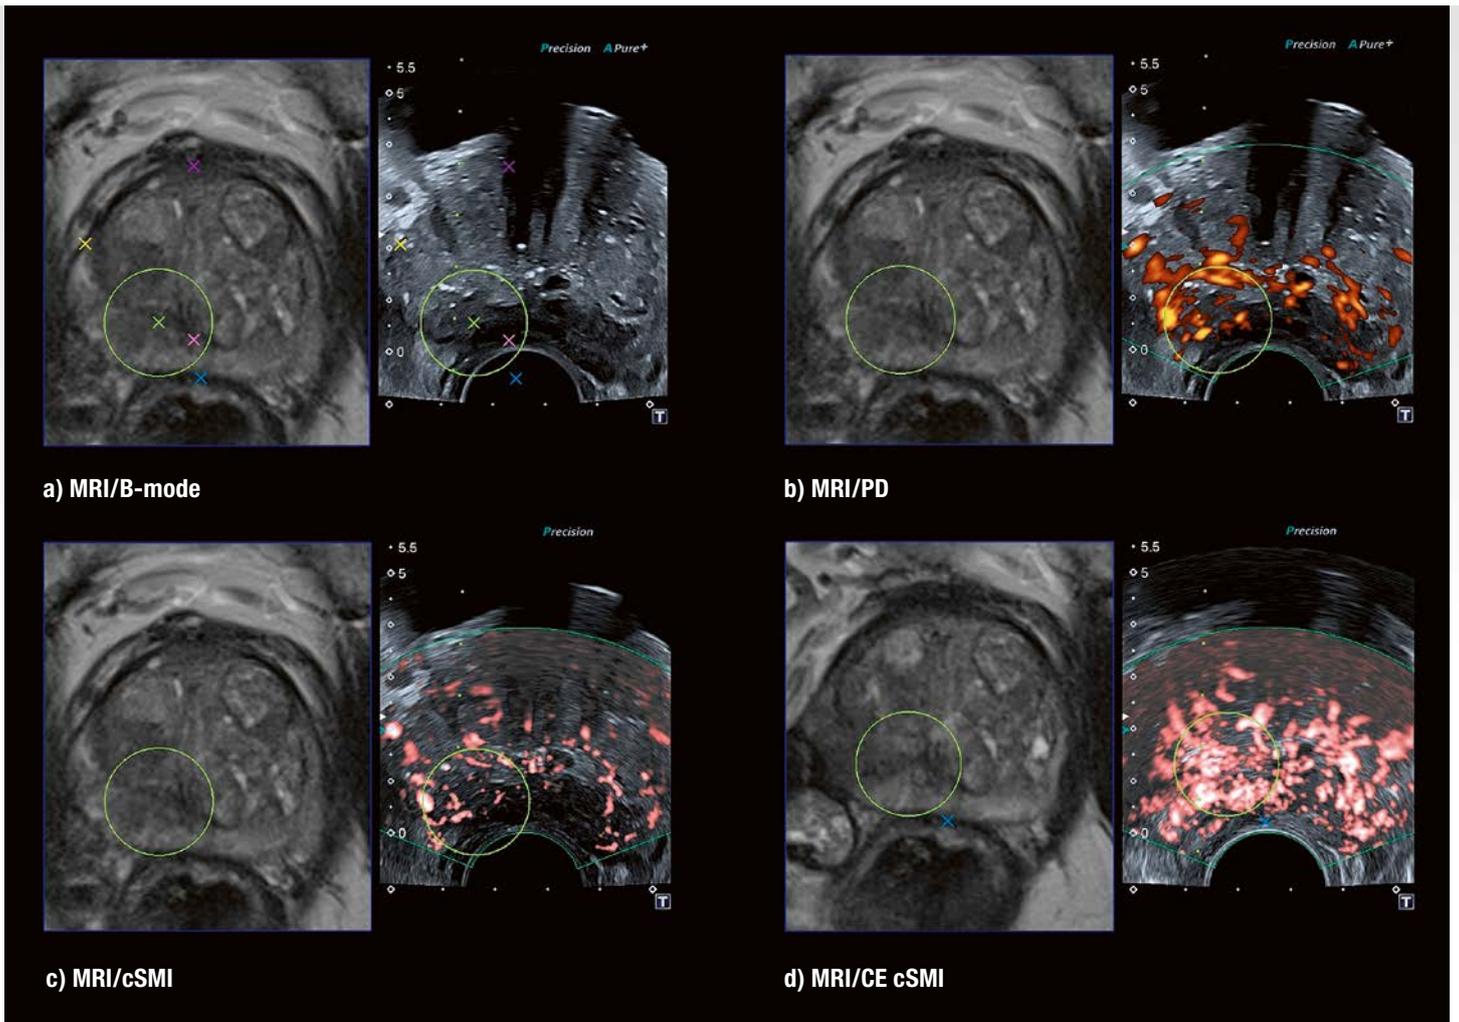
(a–d): US assessment in MRI/US fusion mode: B-mode (a) and PD (b). During the combined performance of SMI (c) and contrast enhanced SMI (d) exact perfusion information with sharp outlines could be obtained.
